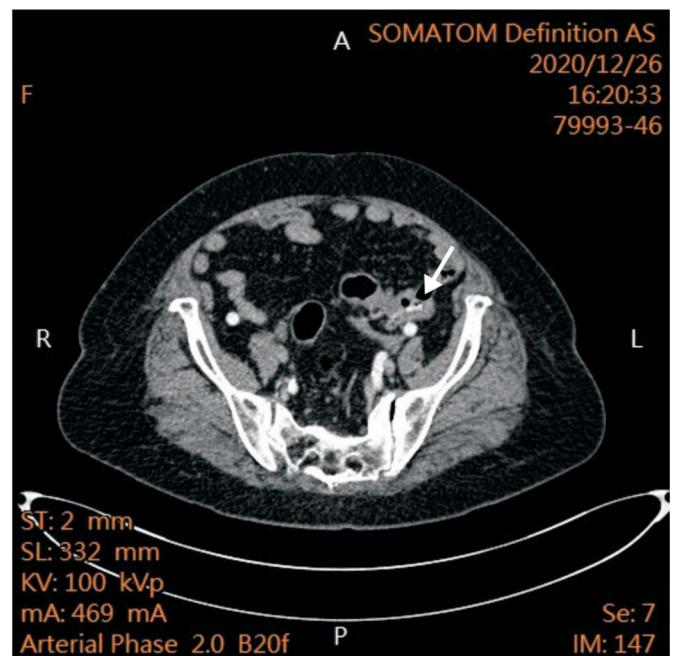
CTA revealed contrast extravasation within sigmoid colon during artery and delay phase.
